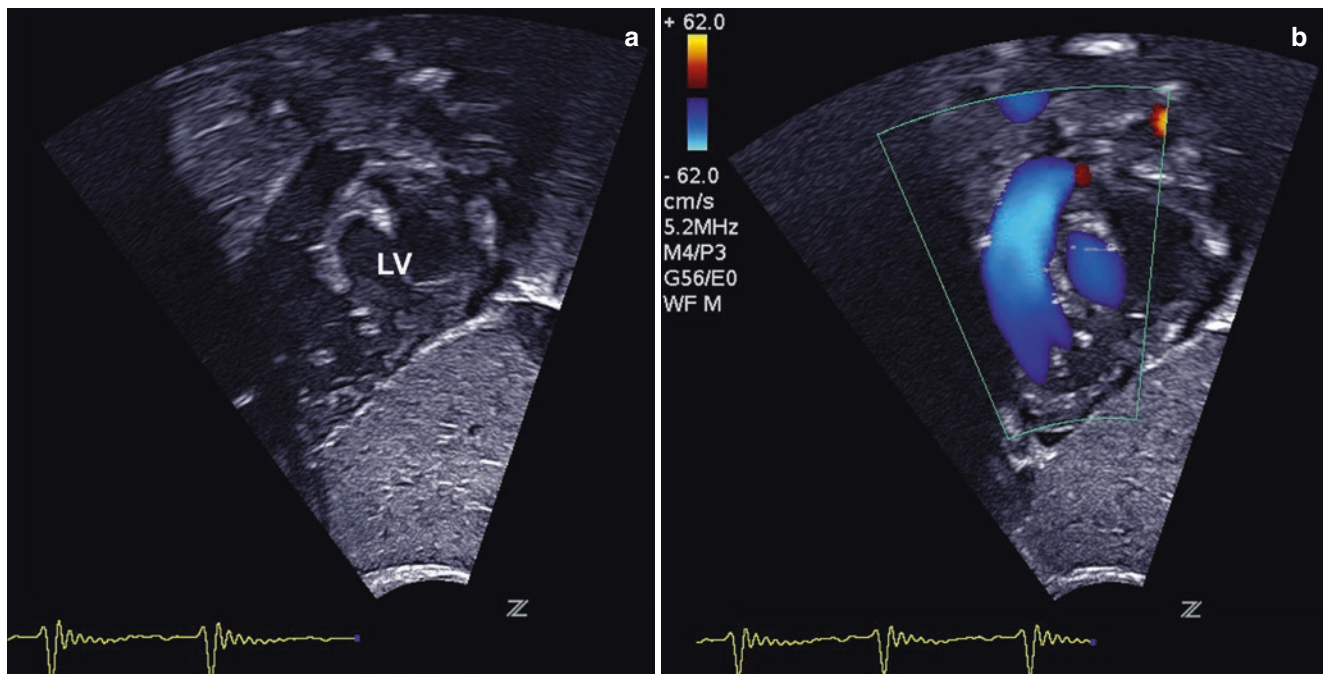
Subcostal coronal view of the right ventricular outflow tract (a) and colour Doppler confirmation of systolic flow to the pulmonary artery (b)
